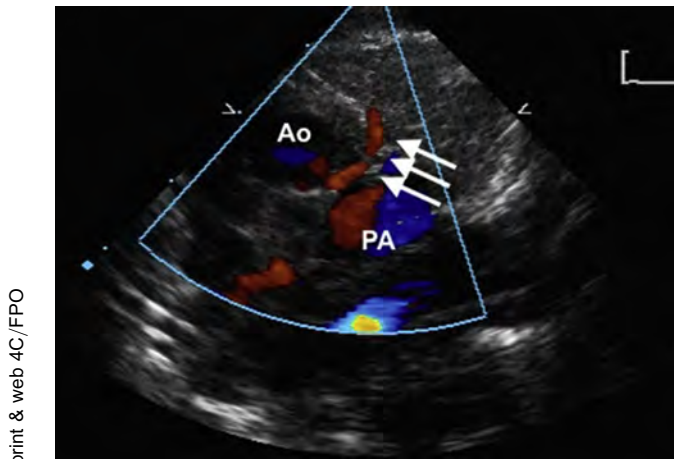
High parasternal view using color Doppler demonstrates an intramural left CA arising from the right-facing sinus, which takes a course between the aorta (Ao) and the pulmonary artery (PA) (white arrows). Transferring this CA to the neo-aorta could result in distortion of the vessel.
